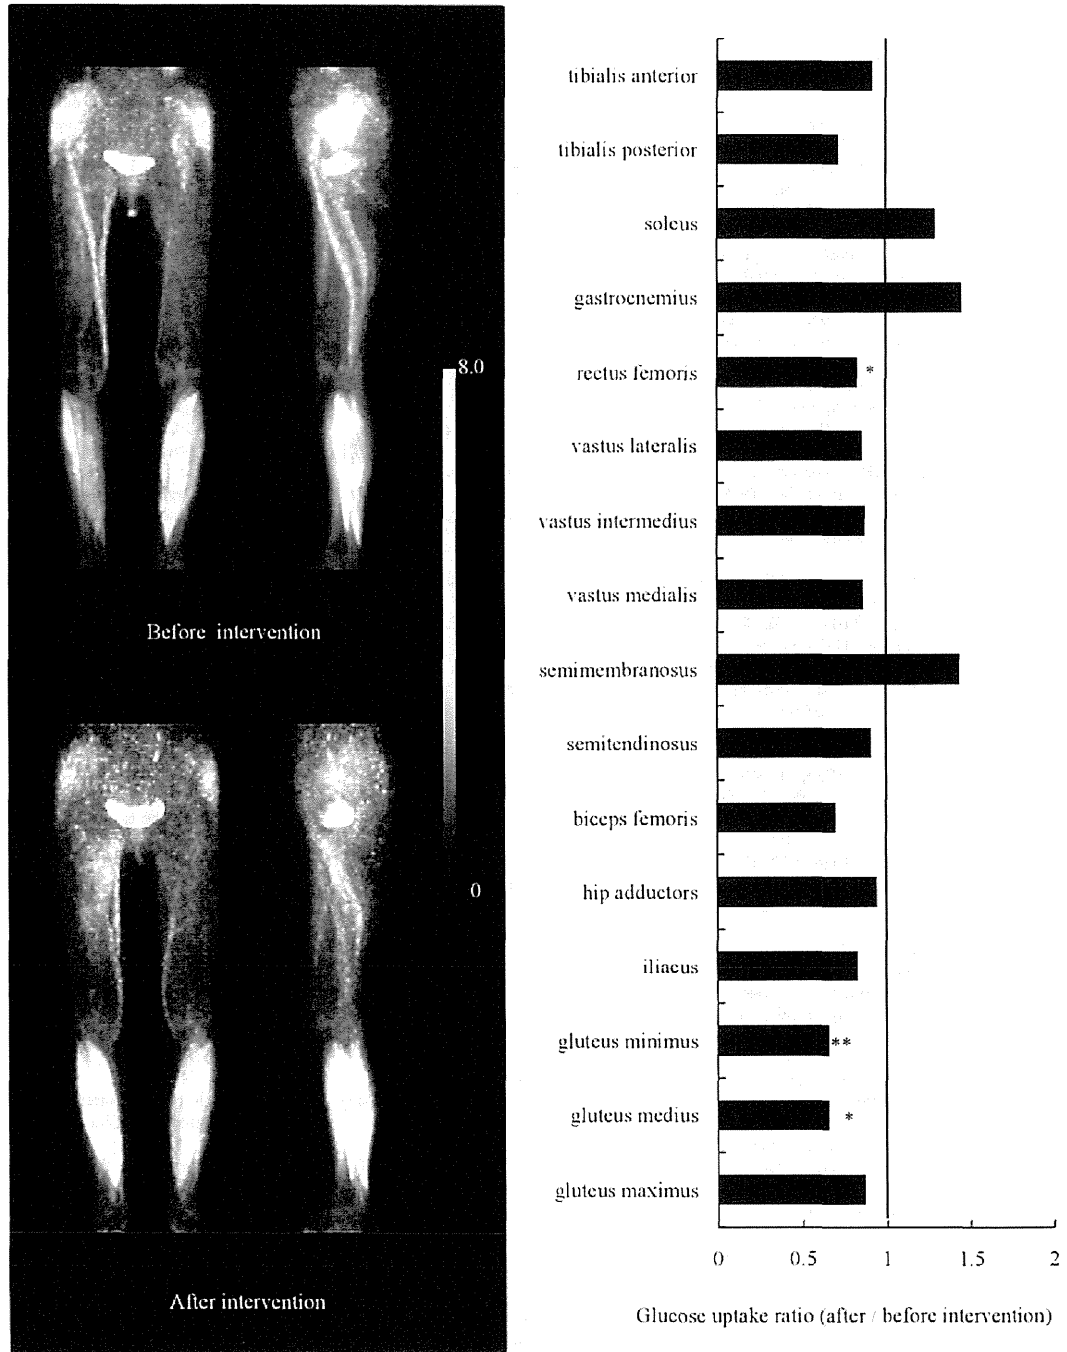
FDG PET images of elderly women before and after the intervention.
